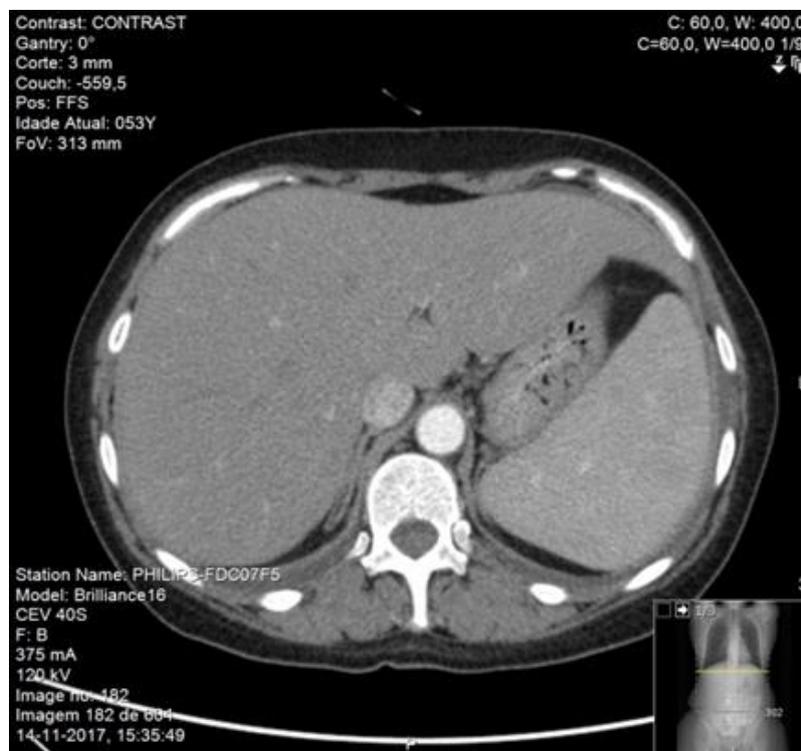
Abdominal CT revealing splenomegaly
